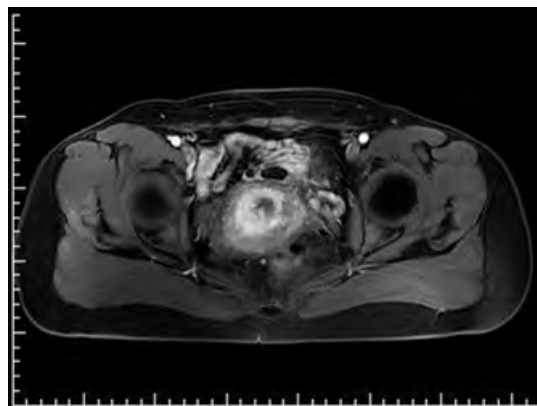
MRI (cross-sectional DWI): The DWI signal of the cervical canal was increased
